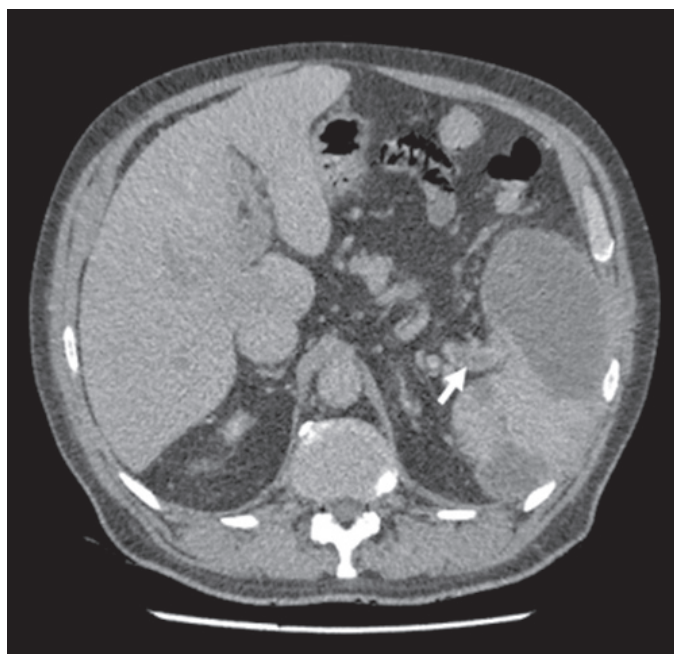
Computed tomography urinary tract with contrast, showing enlarged congested spleen with large areas of non-perfusion secondary to venous congestion due to thrombus in the distal splenic vein (white arrow).
